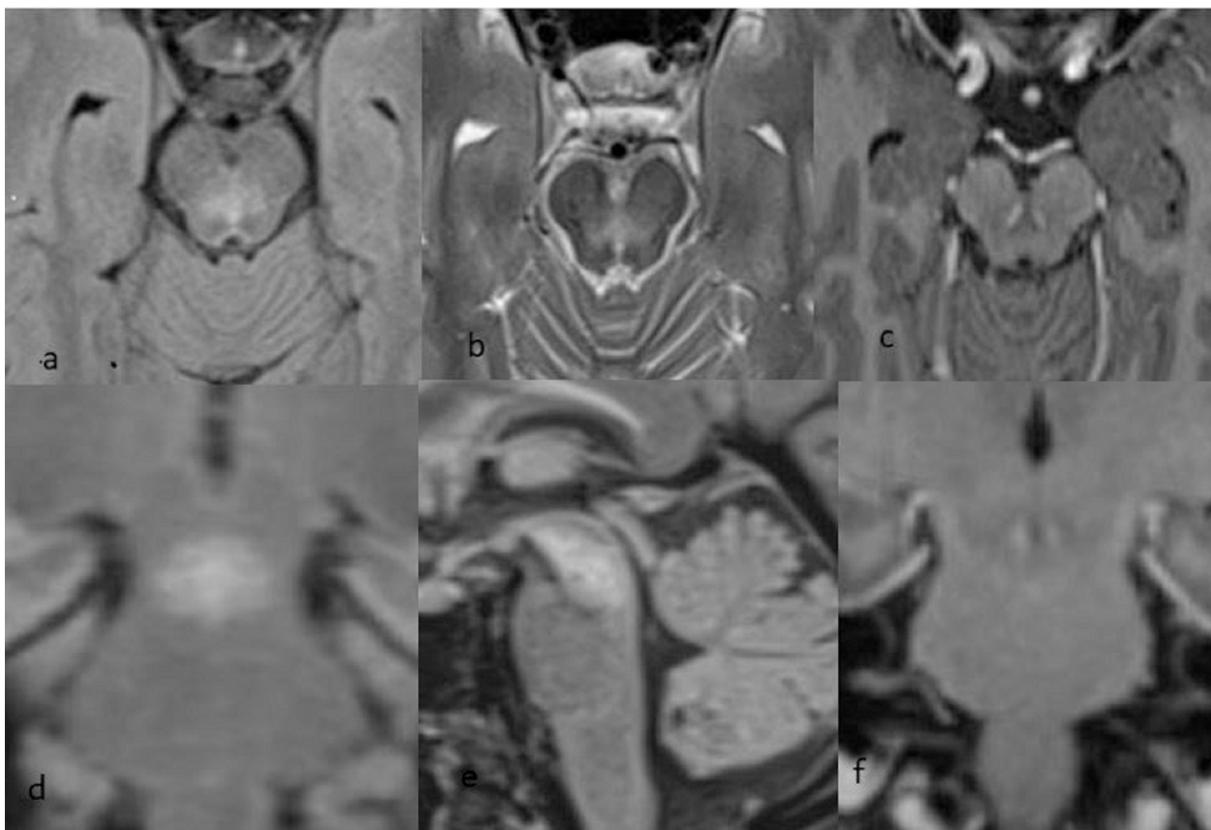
(a) Axial FLAIR, (b) Axial T2 MR, (d) coronal FLAIR and (e) sagittal FLAIR studies showing bilateral tegmental midbrain hyperintensity, enhancing on axial (c) and coronal (f) T1 + gadolinium sequences upon a follow-up MRI examination at 2 months (c).
